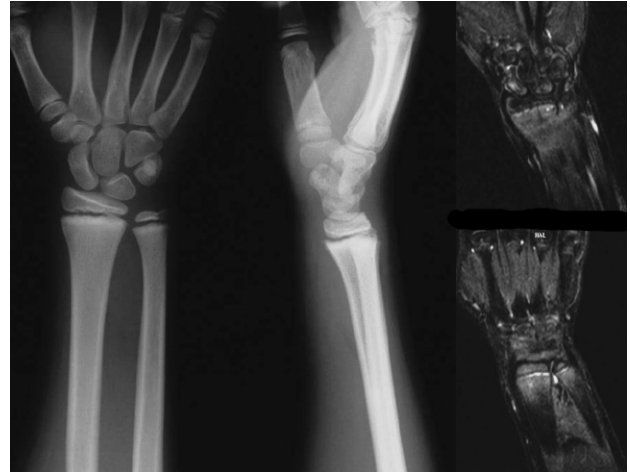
A 13-year-old boy with an undisplaced physal fracture of the distal forearm bones that was treated conservatively. A MRI was performed due to radial-sided wrist pain, following cast removal, 5 weeks post-injury. Short tau inversion recovery images showed bone bruising of the mid-portion of the scaphoid and fluid signal of the distal radioulnar joint.
